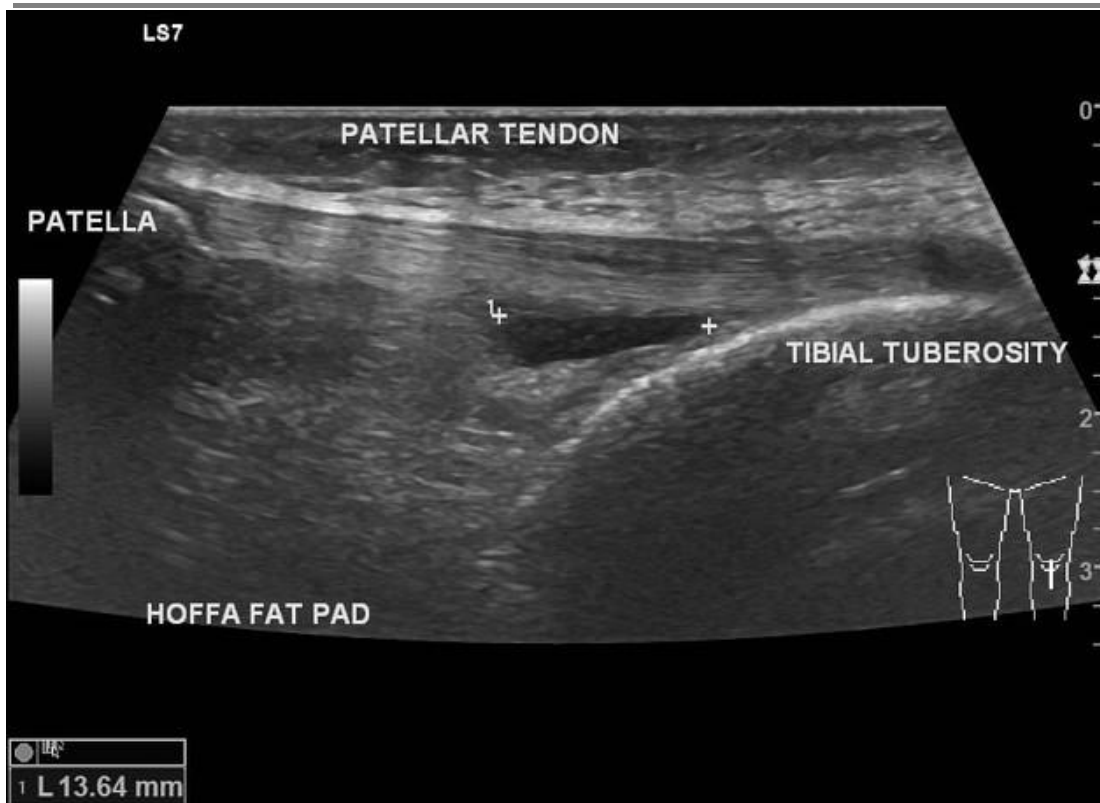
Longitudinal ultrasound image of the anterior knee demonstrating the patellar tendon extending from the inferior pole of the patella to the tibial tuberosity. The Hoffa fat pad is visualized deep to the tendon, and a hypoechoic area is noted at the distal tendon attachment, consistent with focal tendinopathy or partial tear.
